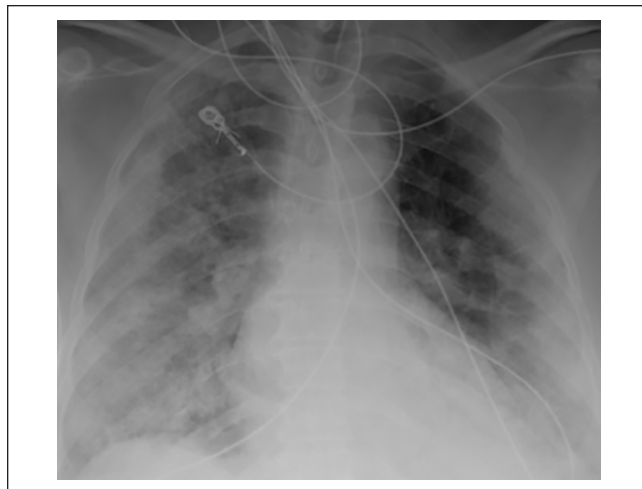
Chest X-ray showing mild-to-moderate pulmonary venous congestion, hazy airspace opacities bilaterally.
